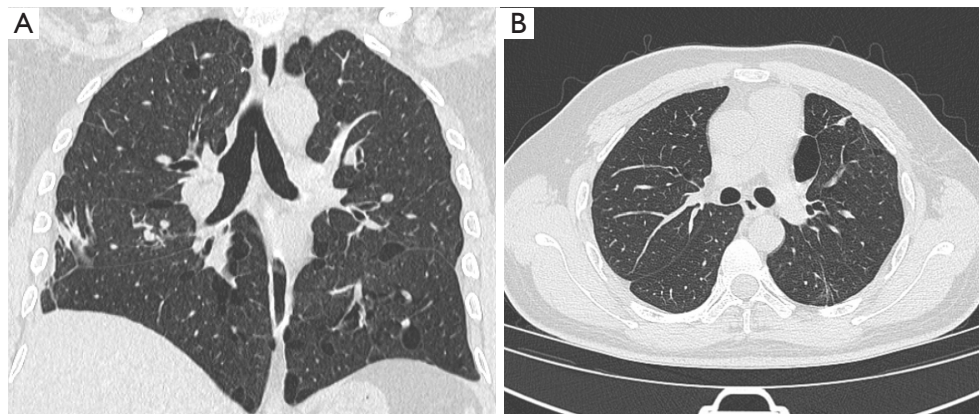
Chest computed tomography (CT) of case B. (A) Coronal CT shows pulmonary cysts, mainly distributed in both lower lungs. (B) The largest cyst is irregular and in the left upper lung.
